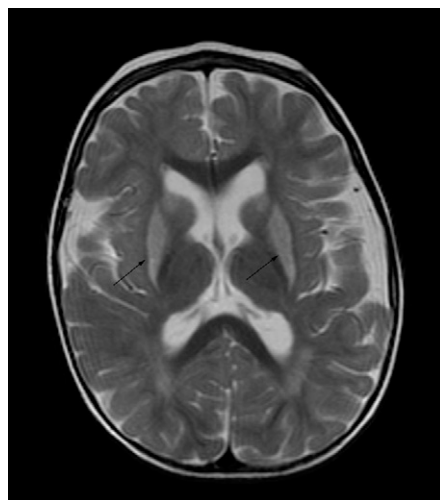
Brain magnetic resonance imaging. The arrows show the hyperintense signal of the caudate nuclei and putamina, as typically happens in patients with GA-I.
